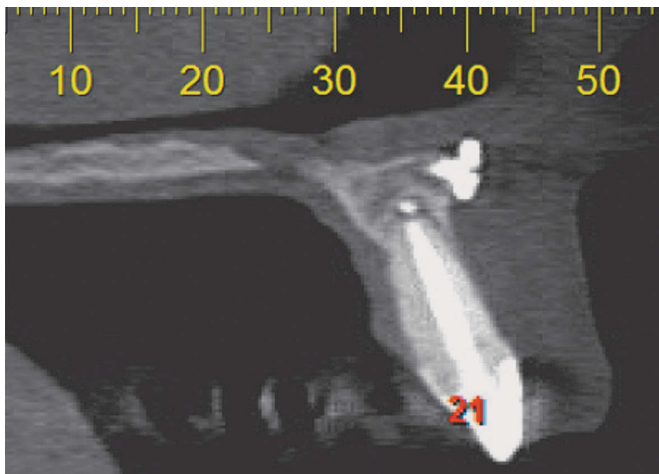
Sagittal and axial tomographic sections taken 2 years after treatment demonstrating regression of periapical lesion.
